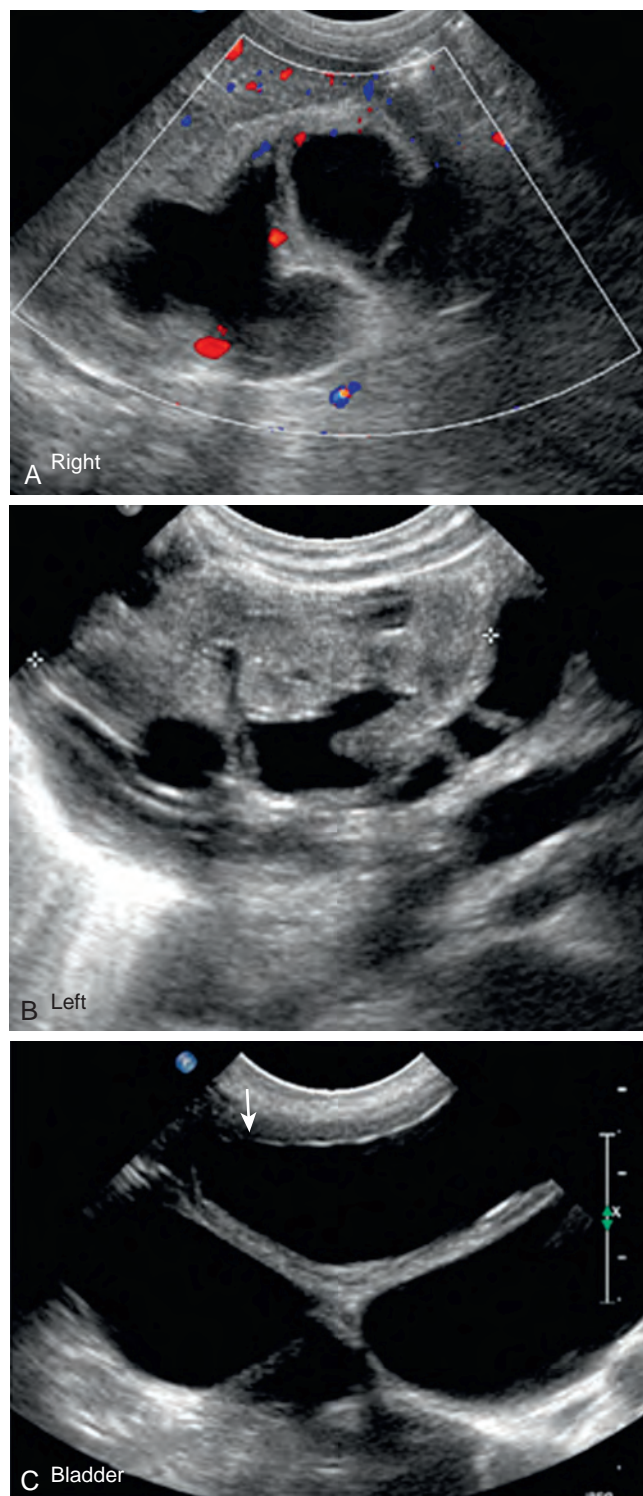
Sonographic example of an infant found to have posterior urethral valve. A and B, Images of the kidneys demonstrate echogenic renal parenchyma, moderate to severe hydronephrosis, and renal cortical cyst (upper pole left kidney). C, Image of the bladder demonstrates significant distal hydroureter bilaterally.
